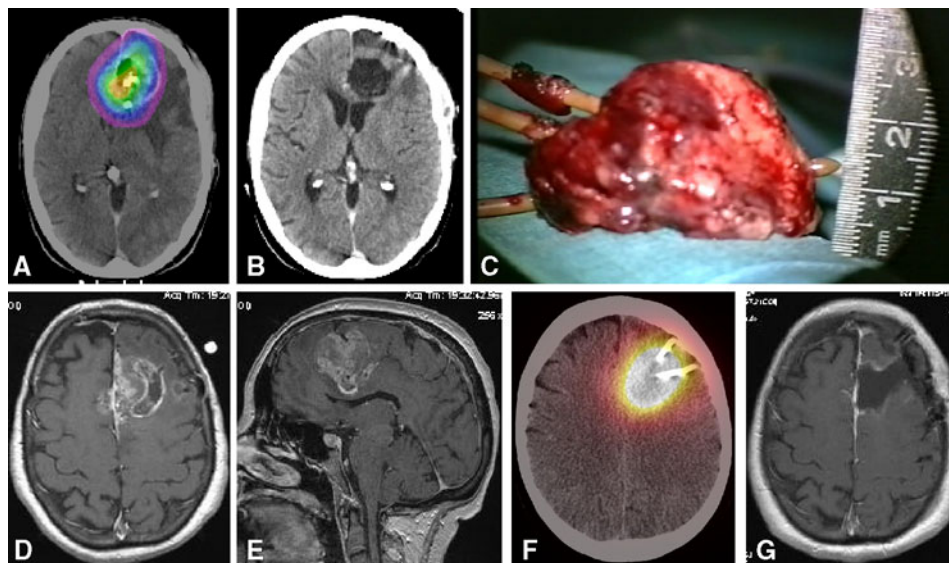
a–c: Patient 10: a Dose distribution as assessed by CT-SPECT at the pretherapeutic intratumoral test injection. b Contrast-enhanced postoperative CT-scan. c En bloc removal of the GBM after internal decompression. Note the capsule-like surface of the resected tumor. The three catheter systems have been left in situ as anatomical
